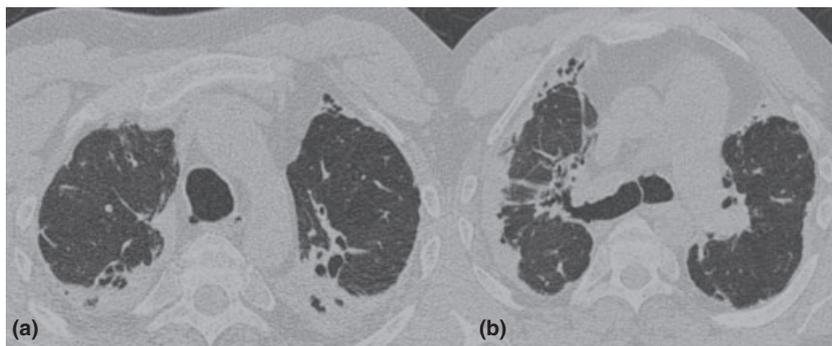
Computed tomography (CT) scan of a patient with chronic pulmonary aspergillosis complicating allergic bronchopulmonary aspergillosis (ABPA). There is extensive bilateral upper lobe cavitation, pleural fibrosis and left-sided bronchiectasis (2A) and marked right-sided circumferential pleural fibrosis with small cavitation within this fibrosis anteriorly, left lingual pleural fibrosis and right-sided proximal bronchiectasis.
